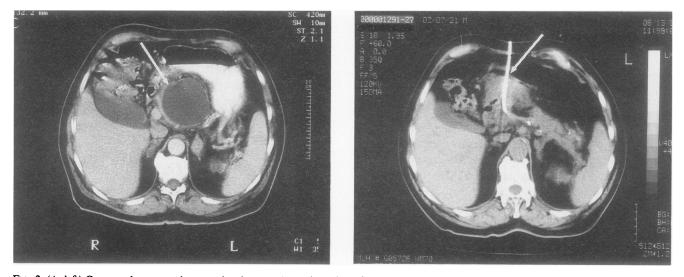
(A, left) Computed tomography scan showing pseudocyst in region of pancreatic head (white arrow). (B, right) Five days later, needle and guidewire localization preceded placement of 8-French pigtail catheter (white arrow) into cyst.
